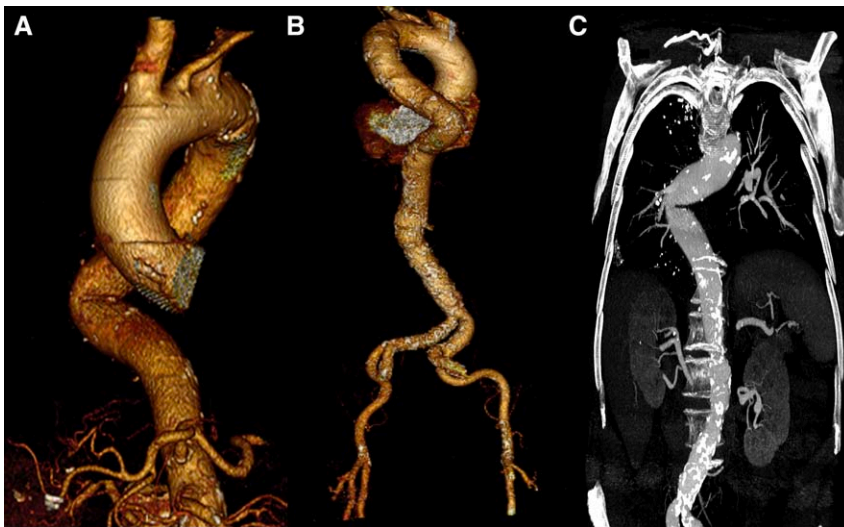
Preoperative computed tomography reconstruction of the arterial tree. A, 3D view of the aortic arch and the thoracic descending aorta tortuosities as seen in the exact implantation fluoroscopic projection. B, Posterior 3D view of all the arterial kinkings to be overcome from the femoral access to the aortic annulus. C, Maximum intensity projection of thoracic aorta showing relationship between aortic tortuosity and calcium distribution.
